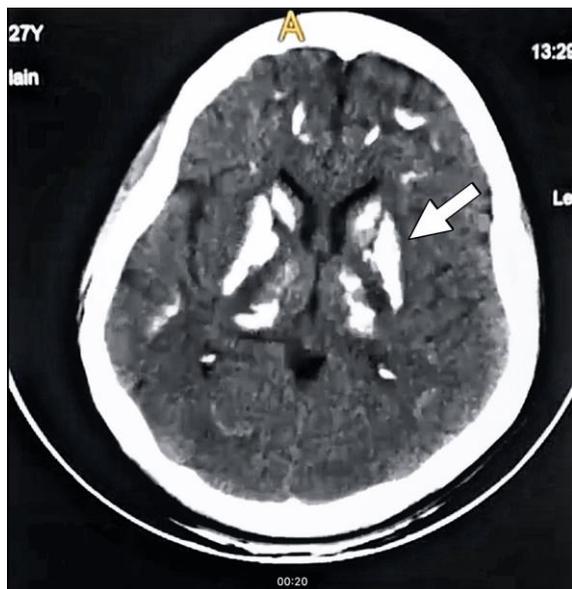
CT scan basal ganglia calcification
